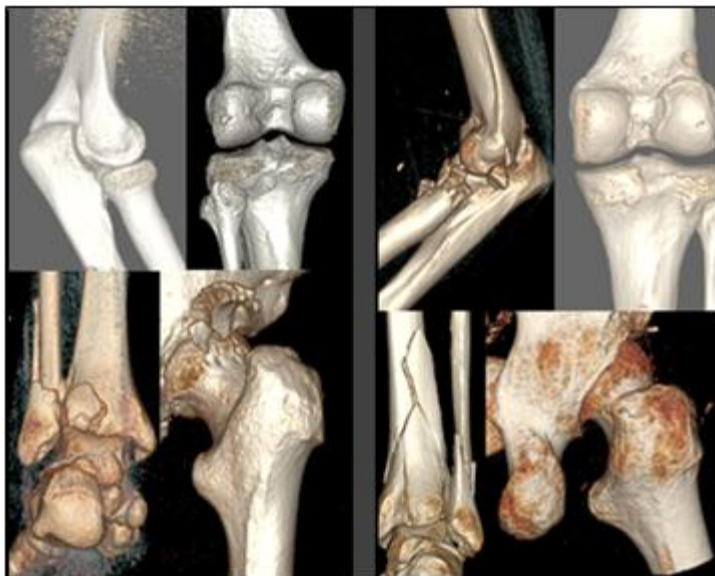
ULD-CT images (left) vs. corresponding C-CT images (right). Nearly indistinguishable resolution with ULD-CT and with a 10x decrease in effective radiation dose (equivalent to 1 chest radiograph).
